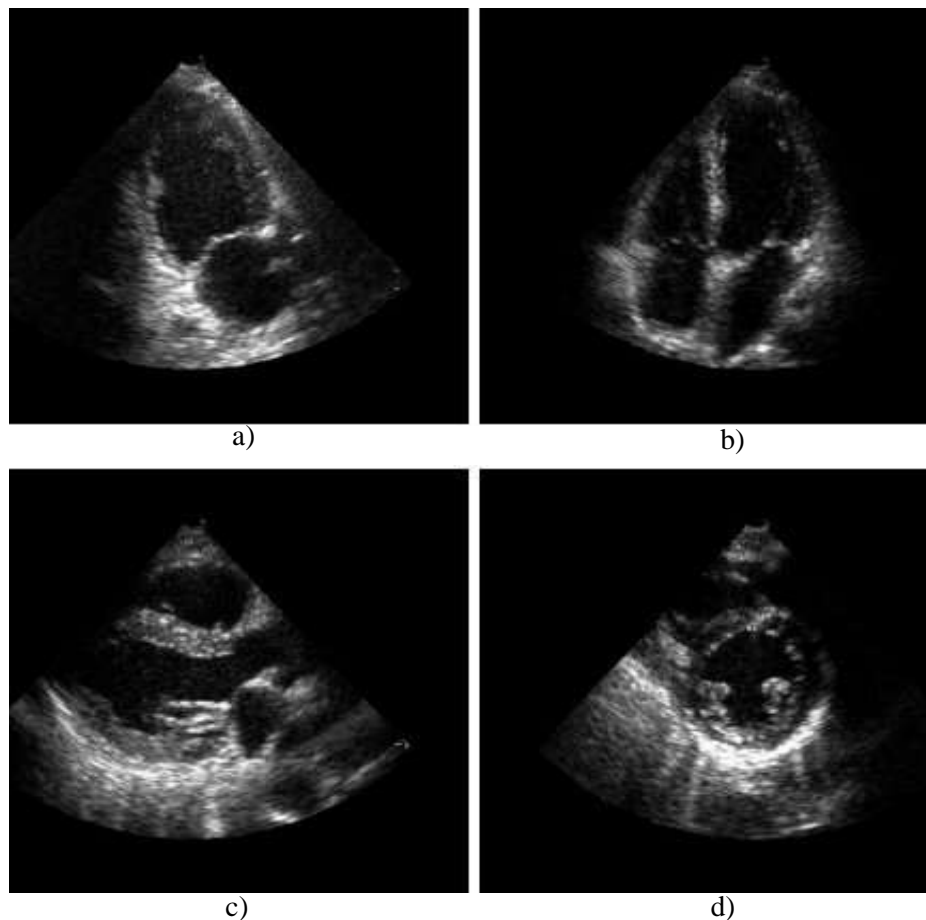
An ultrasound heart images (a) long axis 2-chamber (b) long axis 4-chamber (c) Short-axis base (d) Short-axis mid [26]
